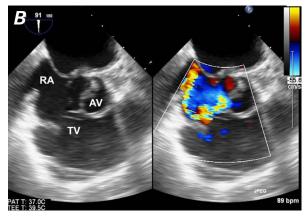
Transesophageal echocardiograms. A) X-plane images show a ruptured aneurysm of the right coronary sinus of Valsalva. B) X-plane image and color-flow Doppler mode reveal the ruptured aneurysm and left-to-right shunting into the right atrium.
